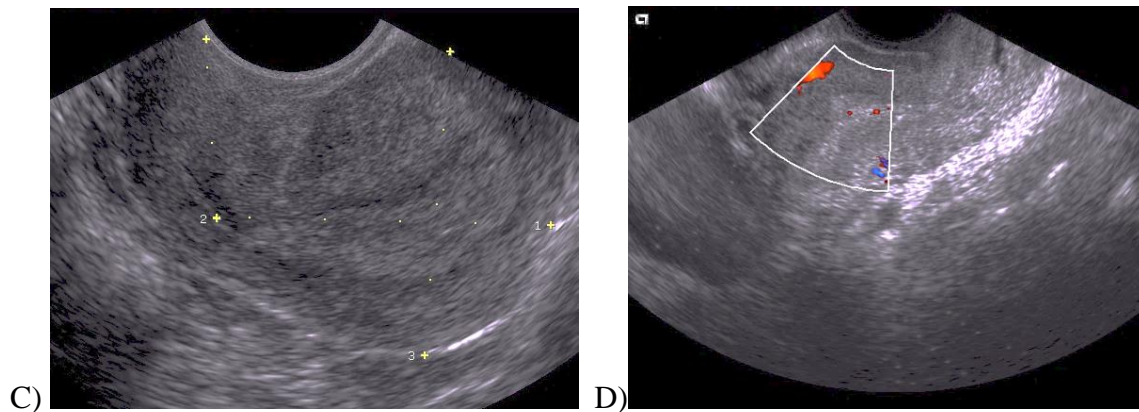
Figure (A), (B) and (C) - TVS images shows lobulated hyperechoic lesion in endometrial cavity, Figure (D) On colour doppler increased vascularity (multiple vascular pattern) is seen s/o neoplastic mass lesion.
